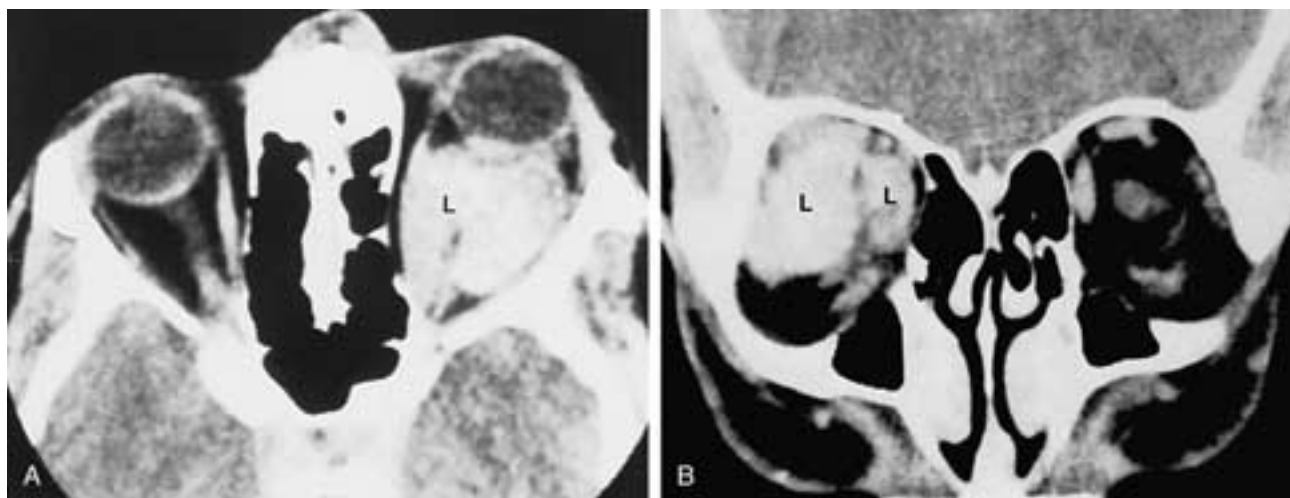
Lymphangioma. A, Contrast-enhanced axial CT scan. B, Coronal CT scan. A and B show a large lobulated lymphangioma (*L*).
